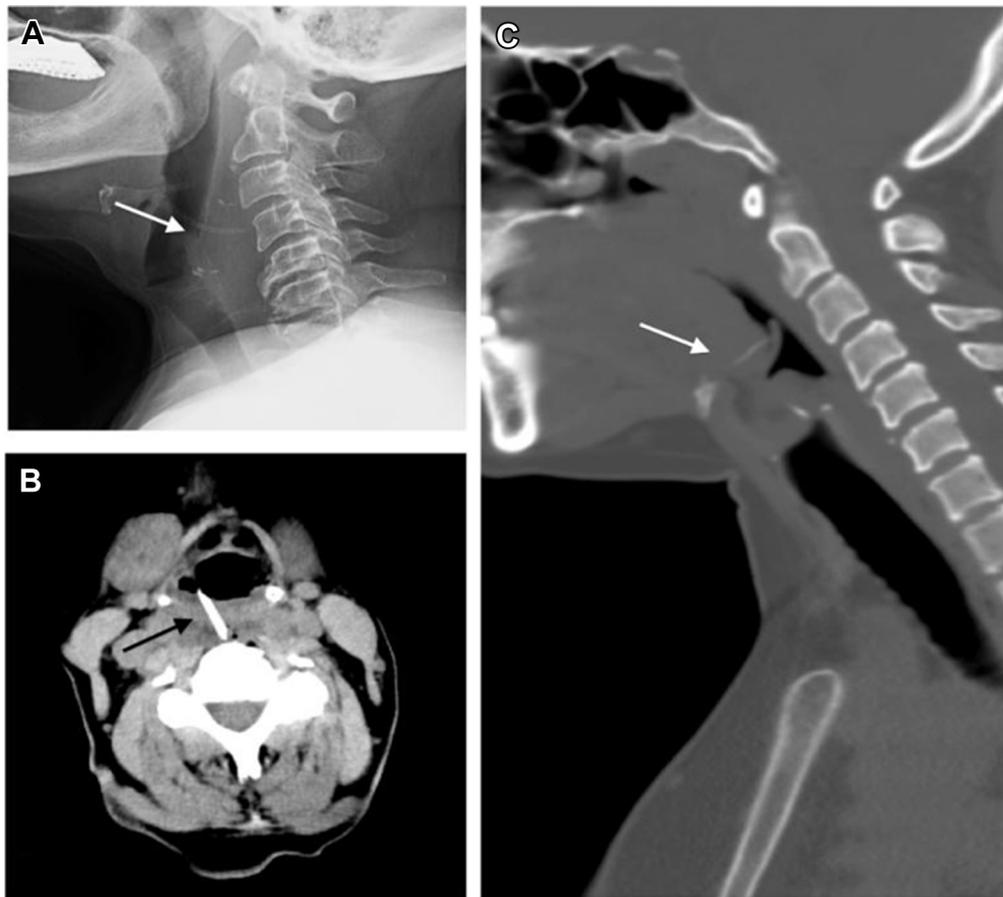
Patient who swallowed a chicken bone. Lateral neck soft tissue radiograph (A) demonstrates a faint radiopaque curvilinear structure (white solid arrow) anterior to C4, with prevertebral soft tissue swelling at the same level (helpful secondary sign even in absence of radiopaque FB). As a rule of thumb, prevertebral soft tissue swelling is present if soft tissues are thicker than half a vertebral body width at C3 or above or a vertebral body width at C4 or below. Axial CT view (B) of the same patient demonstrates a hyperdense chicken bone (black solid arrow). Sagittal view of a neck CT of another patient who swallowed a fish bone (C) demonstrates a faint radiopaque linear structure within the vallecula (white solid arrow), consistent with a fish bone, which would appear radiolucent on radiographs.
